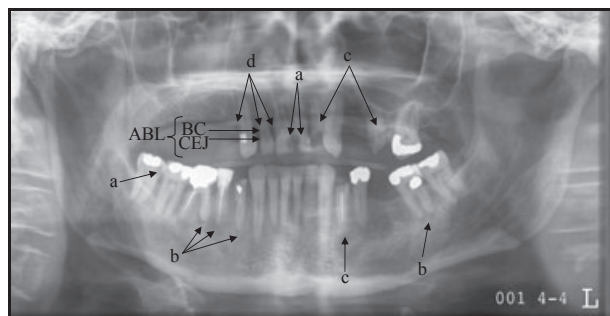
Panoramic x-ray of a patient with alcohol cirrhosis. Sixteen teeth were extracted before liver transplantation. Infectious dental foci included: a = deep caries cavities, b = apical periodontitis, c = root remnants, and d = teeth with severe attachment loss. CEJ, cementoenamel junction; BC, bone crest; ABL, alveolar bone loss which is measured as the distance between CEJ and BC.
